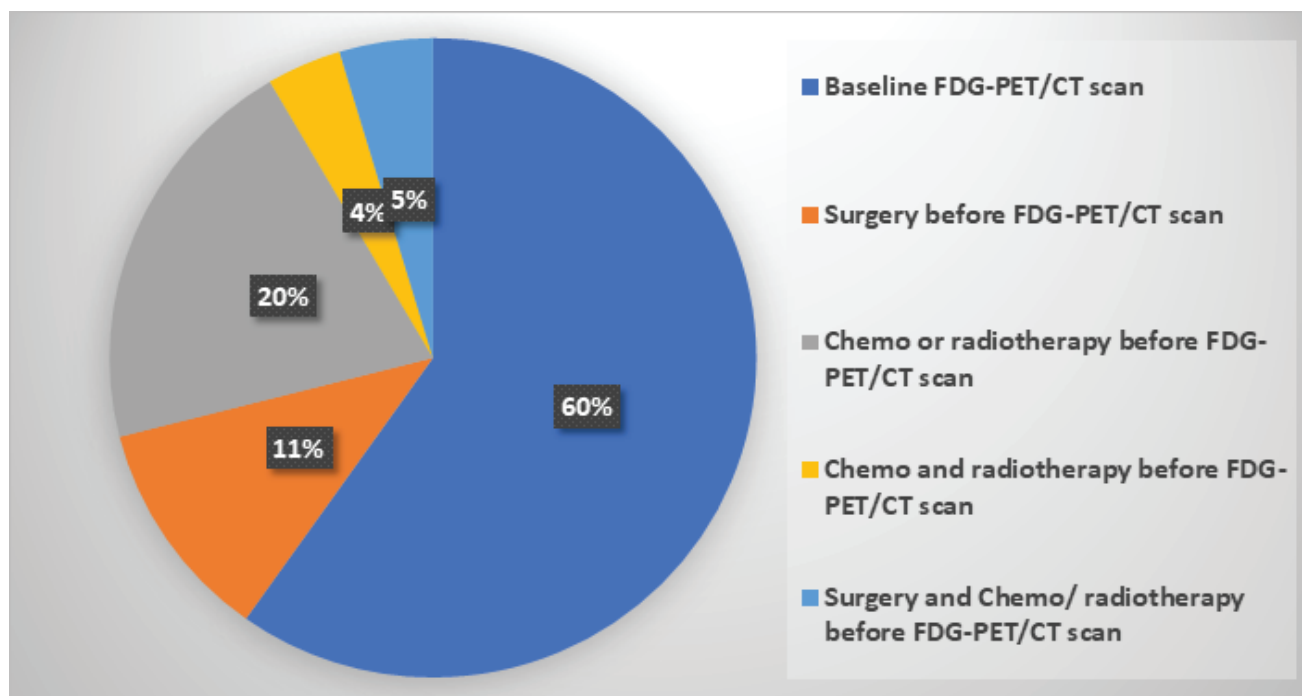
Baseline PET-CT imaging and treatments received by the patients
